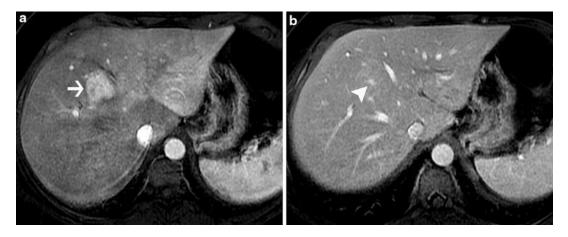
Focal nodular hyperplasia (FNH). A liver mass was seen incidentally on abdominal US in a 26-year-old woman who presented with abdominal pain. The patient was referred to liver MRI for further characterization. Axial, fat-suppressed, enhanced MRI (a) at early arterial phase shows markedly and diffusely enhancing mass
